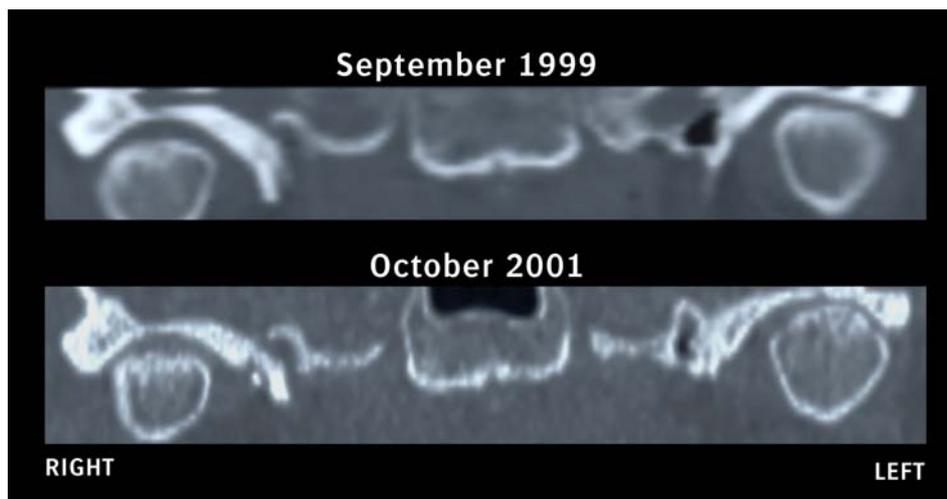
Frontal view of computed tomography. At the first examination (September 1999) sign of erosion was present in the central part of the right mandibular condyle. At the second examination 32 months later (October 2001) signs of erosion were present in the lateral, central and medial part of the right mandibular condyle as well as flattening. Sign of erosion was also present in the lateral, central and medial part of the left mandibular condyle. The blood level of S-5-HT decreased (1486.0 → 600.0 nmol/L) and P-HT, while P-TNF α levels increased (12.9 → 57.0 nmol/L; 15.4 → 51.0 pg/mL, respectively) during the observation period.
